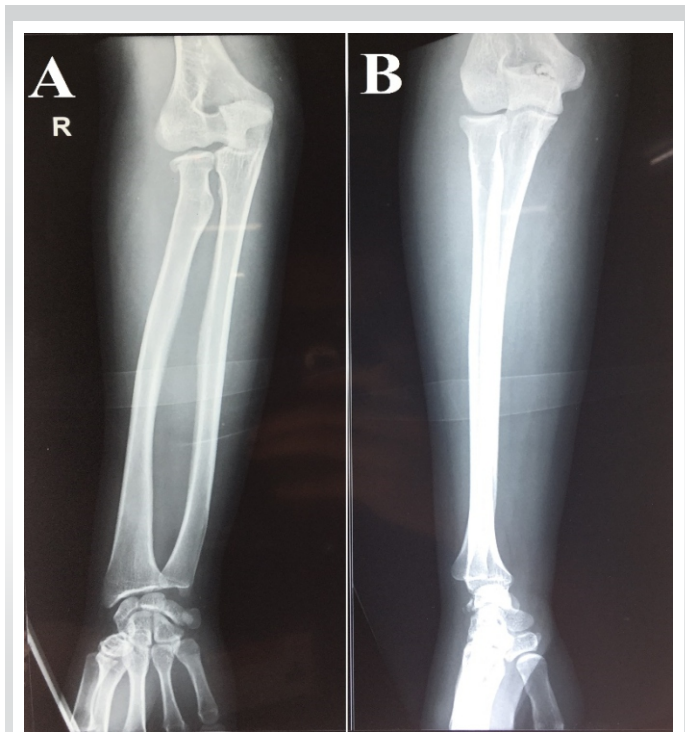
Radiograph of the forearm done at the time of injury. (a) Anteroposterior view showing lateral subluxation of the ulna. (b) Lateral view of the forearm. The ulnohumeral joint appears normal in this radiograph.
